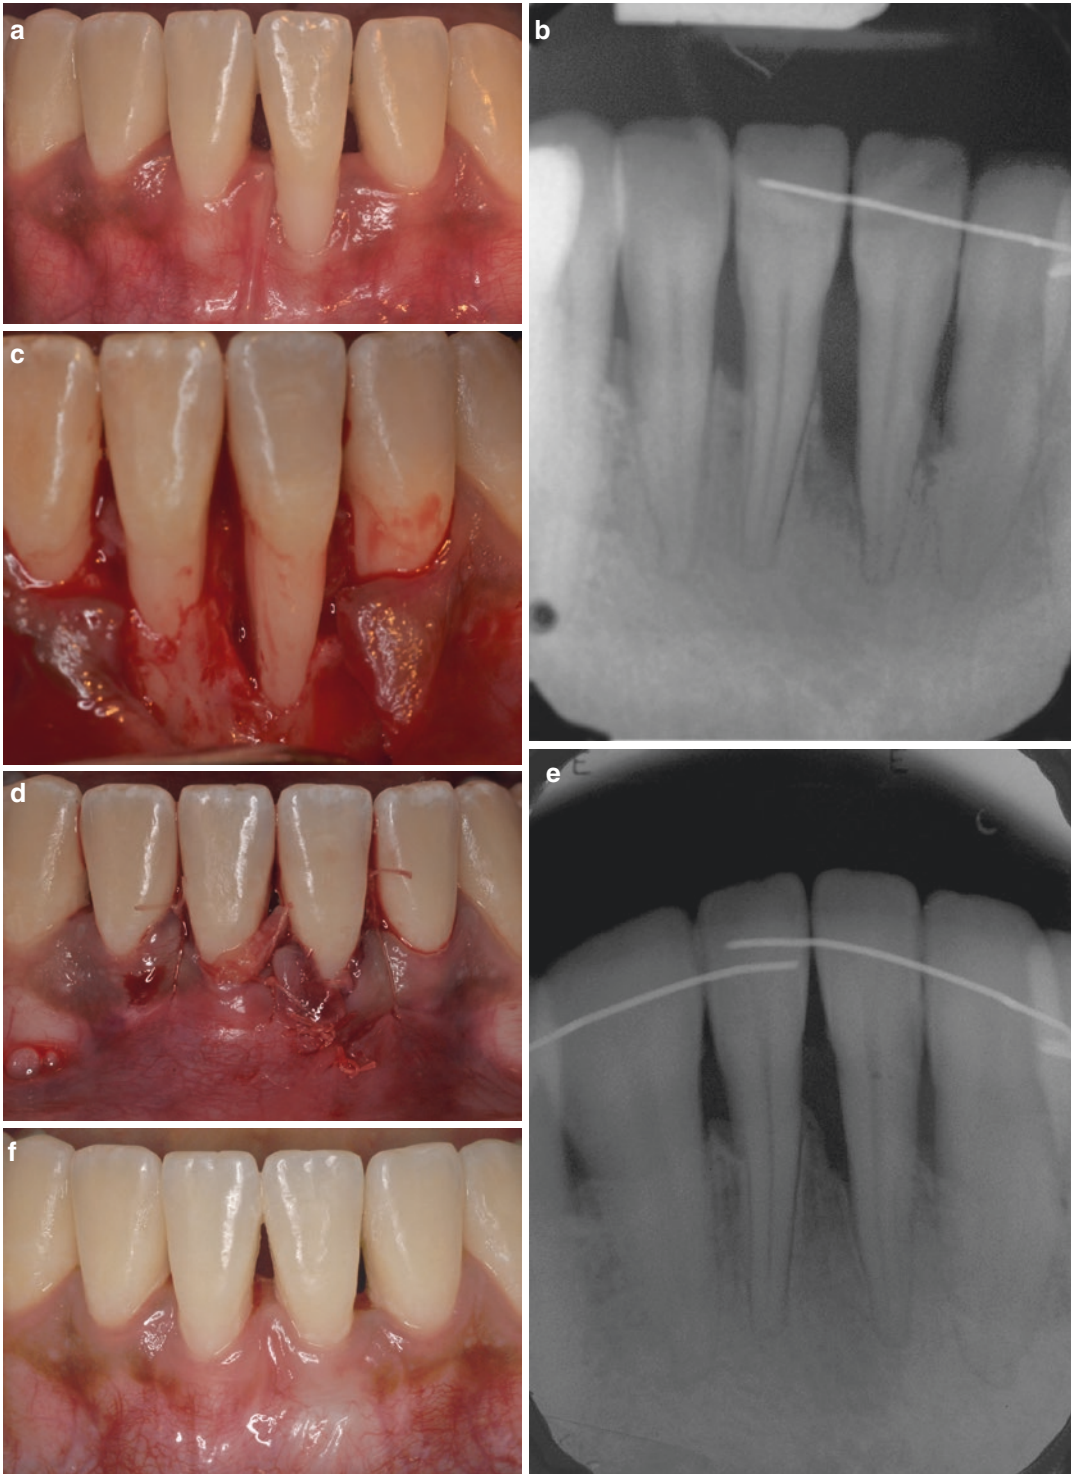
(a). Gingival recession involving 360° around the lower anterior teeth (class IV) is evident. (b) Periapical radiograph shows large loss of periodontal support around
